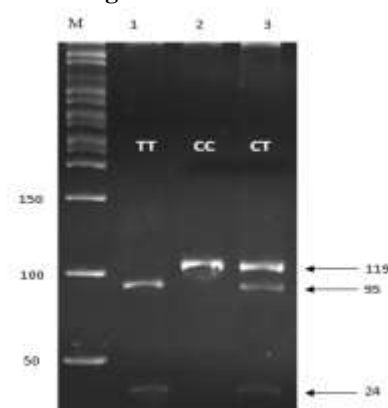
PCR-RFLP results for CEBP1 gene polymorphism in agarose gel 4%. M: 50-bp molecular weight index (50 bp), column 1: mutant homozygote (TT), column 2: healthy homozygote (CC), column 3: heterozygote (CT).
